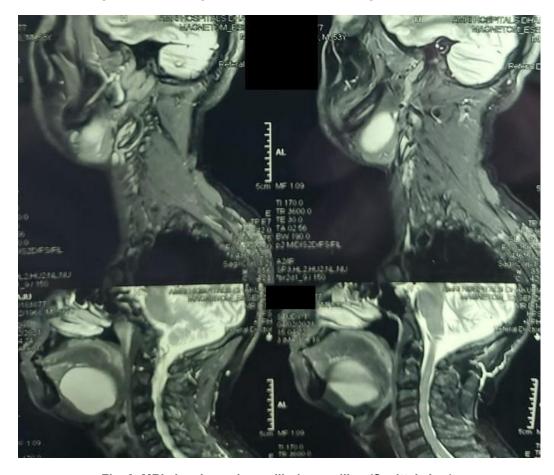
MRI showing submandibular swelling (Sagittal view)
